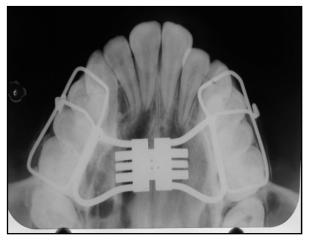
Upper Occlusal radiograph with HYRAX
